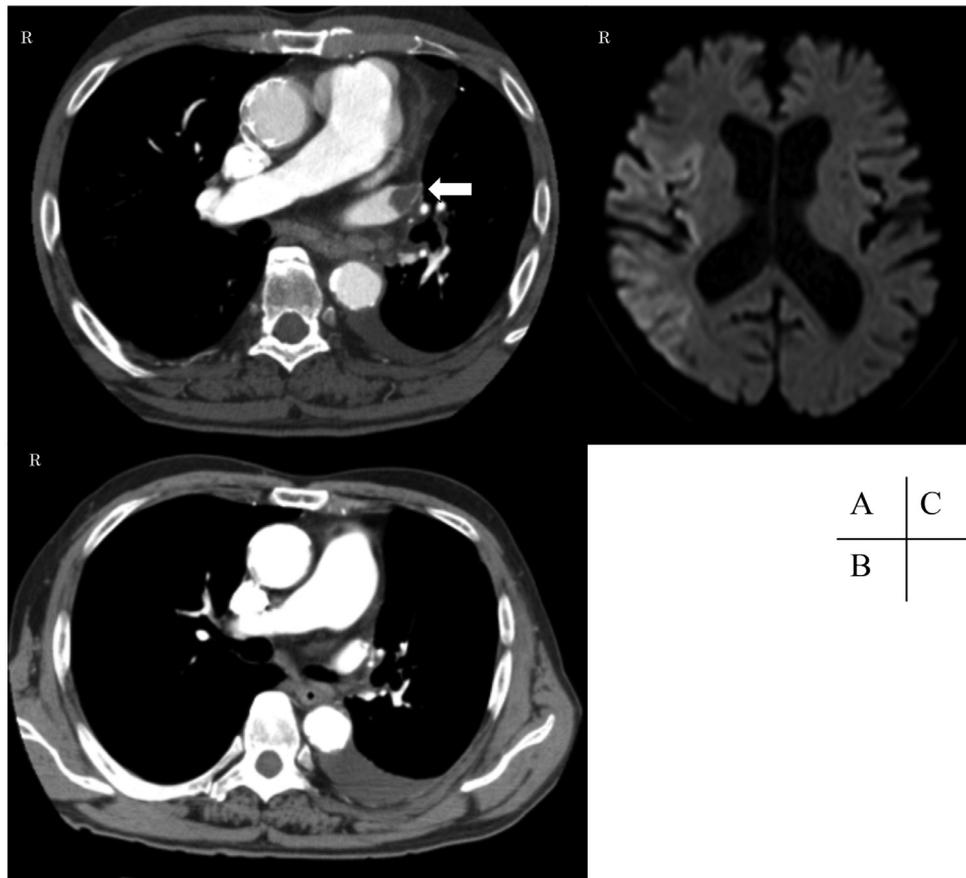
In case 3, the thrombus in the left superior pulmonary vein stump after lobectomy was evident on CECT on POD 4 (A, arrow), but not on POD 18 (B). MR imaging with diffusion-weighted images detected areas of hyperintensity in the territory of right MCA on POD 2 (C).
